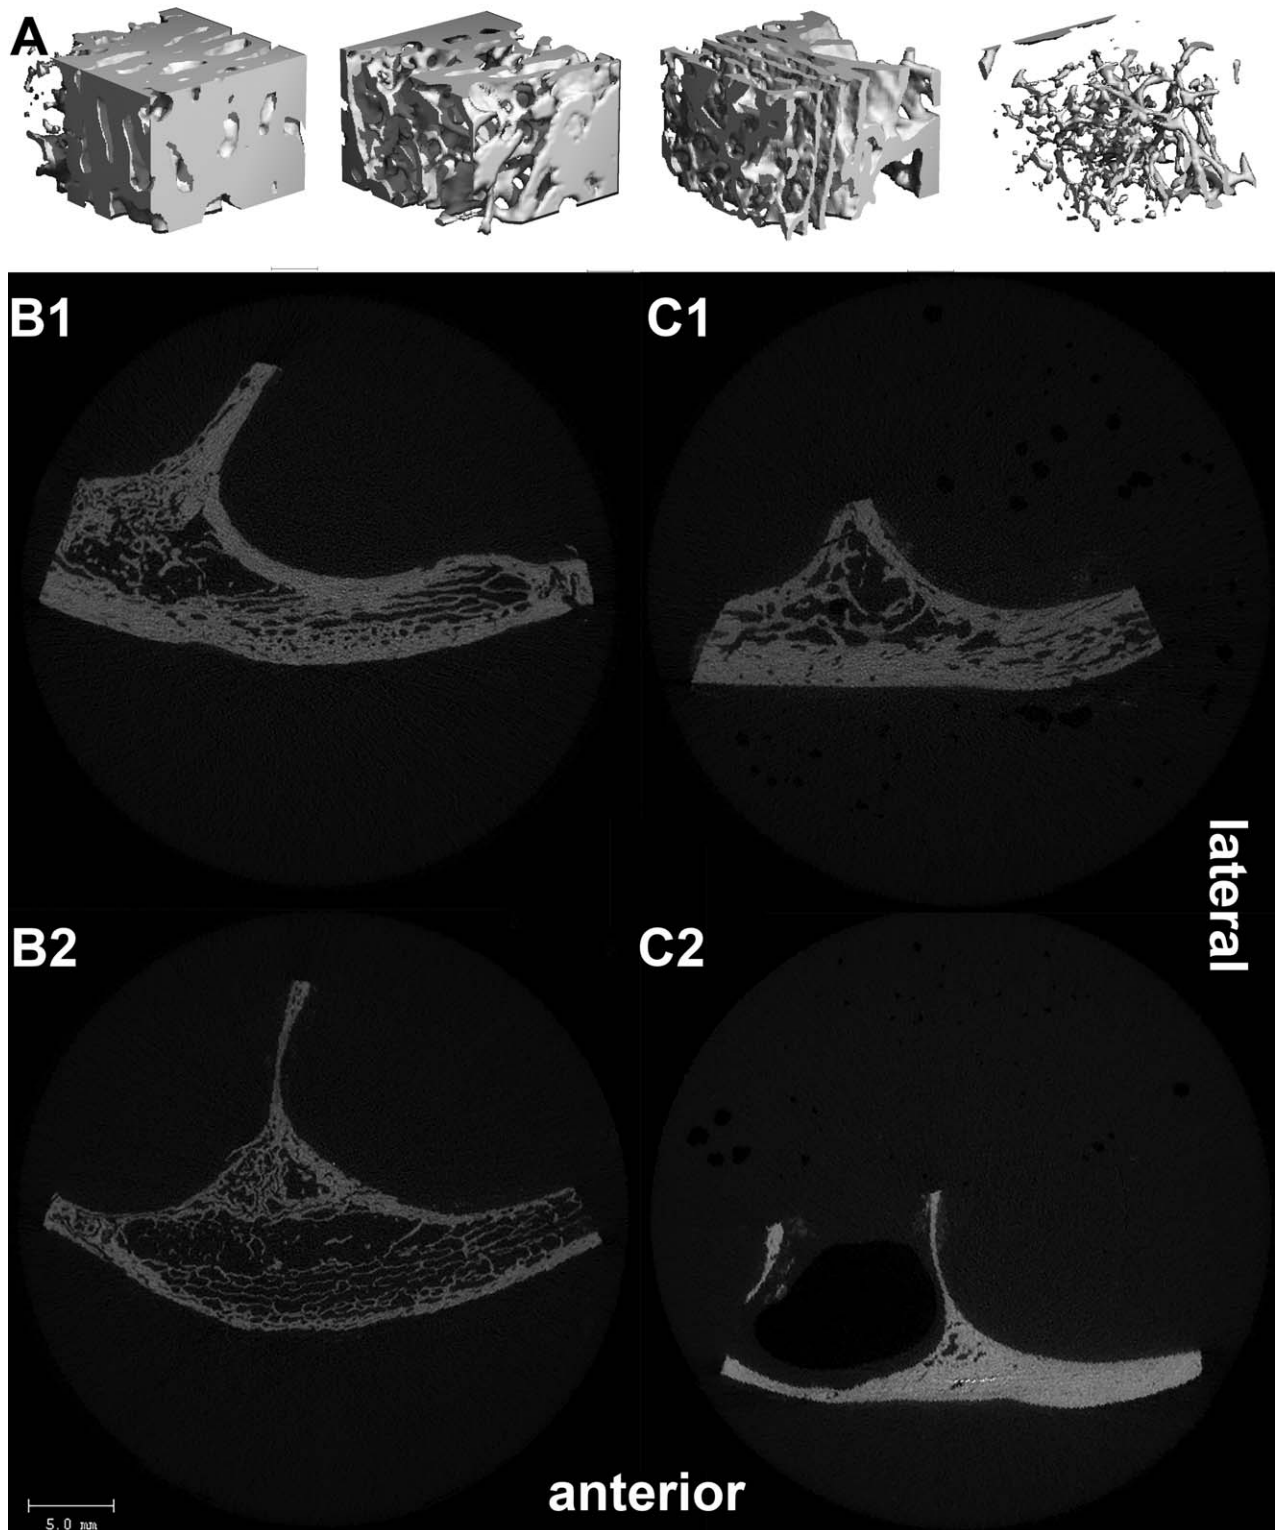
A: Rectangular regions measuring approximately 25 mm<sup>2</sup> and 10-mm thick of trabecular bone rendered from human lower zygomatic body regions, showing individual and intraspecific variability in trabecular structure throughout this region. B: Transverse section of a  $\mu$ CT scan of a human zygomatic body (1, 2) showing plate-like trabecular structure in the lateral end transitioning to more sparse rod-like
